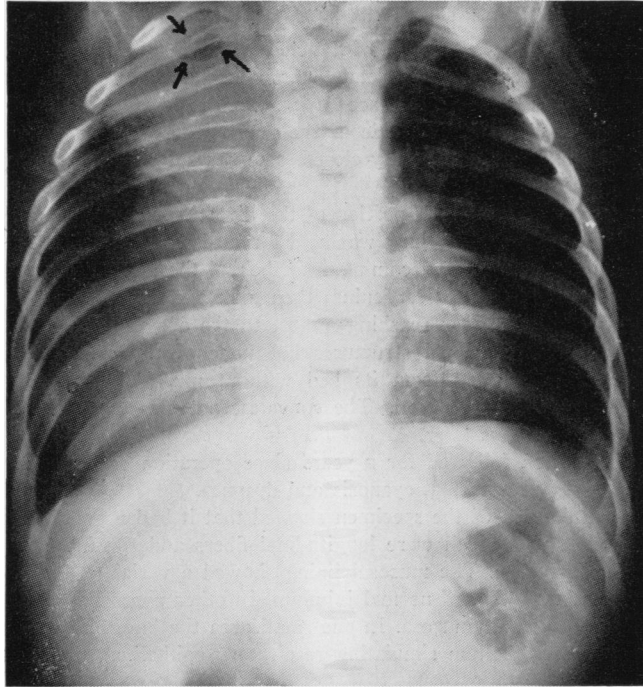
(Case 2.) Preoperative roentgenogram showing the large diverticulum projecting out from the right side of the mediastinum. Arrows indicate gas bubble in the structure. (The central groove or depression was caused by the azygos vein which constricted the diverticulum).
